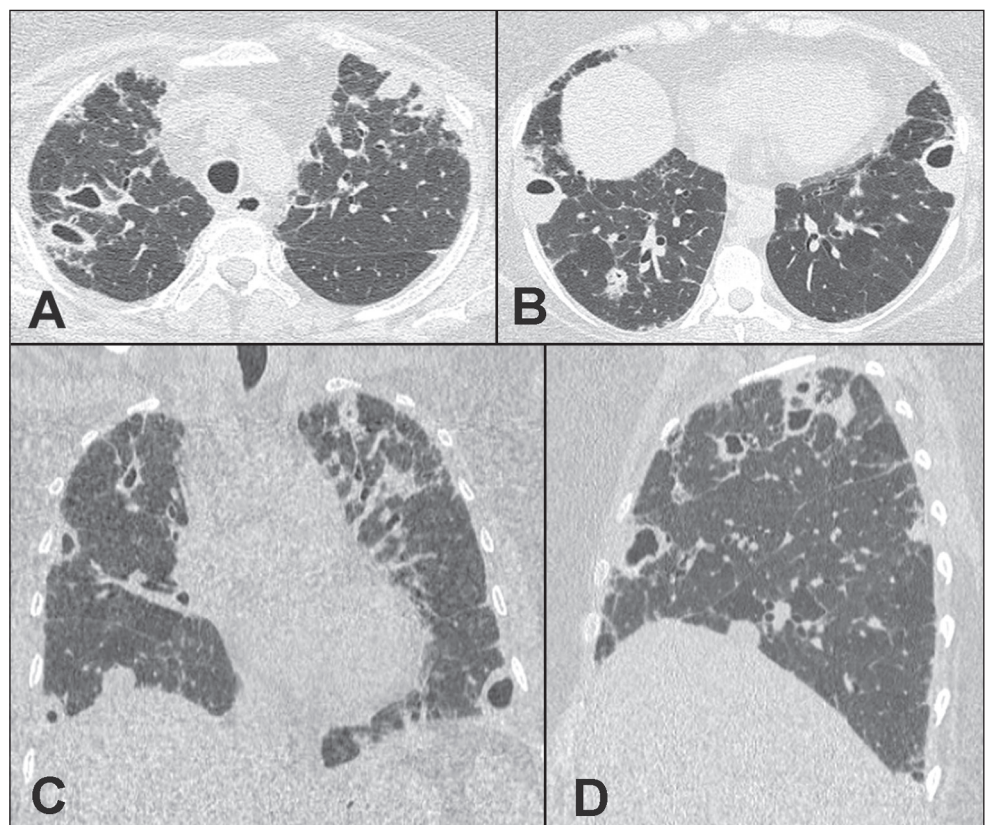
Computed tomography of the chest, in axial views (A,B), a coronal view (C), and a sagittal view (D), showing multiple nodular lesions with different degrees of cavitation, some with air-fluid levels. Note also the discrete subpleural opacities with reticulation.
